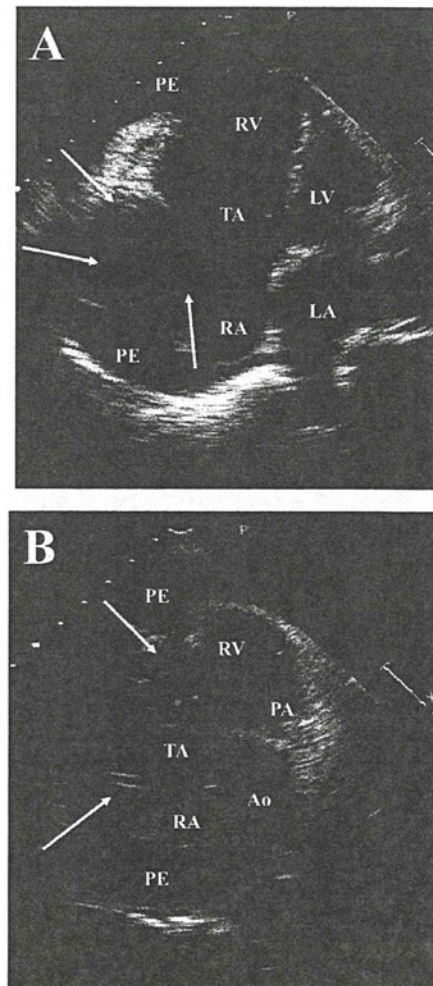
Two-dimensional transthoracic echocardiograms on admission in the apical 4-chamber view (A) and short-axis view (B) show the large invasive cardiac tumor (white arrows) protruding into the right atrium (RA) and right ventricle (RV), and causing an RV outflow tract obstruction. PA, pulmonary artery; PE, pericardial effusion; TA, tricuspid valve annulus; LA, left atrium; LV, left ventricle; Ao, aorta.
